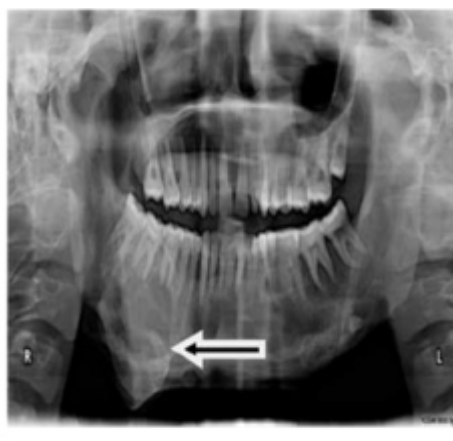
Orthopantomogram showing Multilocular radiolucent lesion (arrow) present in right side of mandible involving body. Typical loss of lamina dura was not very evident.
